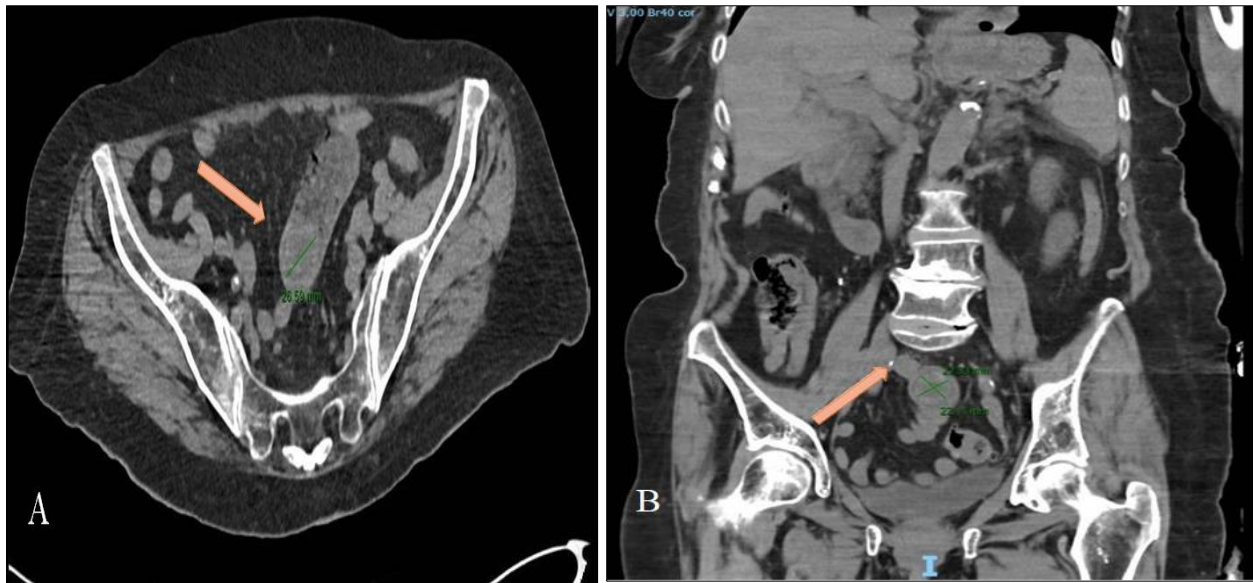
CT images showing the gallstone (arrows) in the small intestine. A: axial section. B: coronal section
